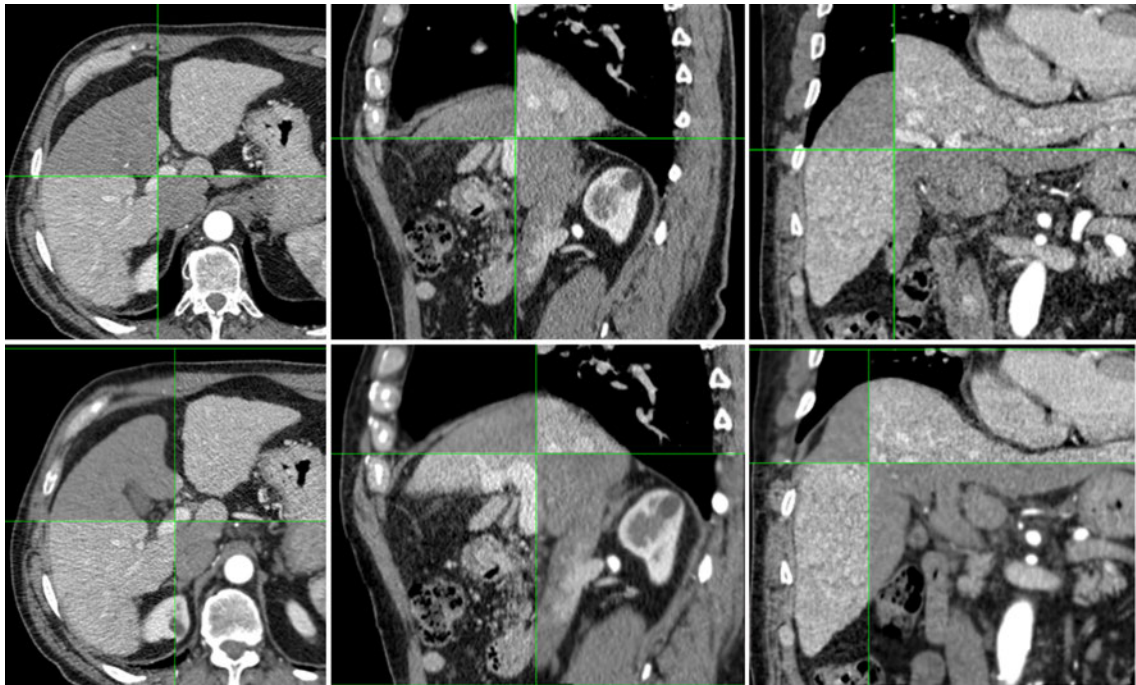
Registration of arterial CT contrast phase with portal venous phase of the liver. The top row shows the alignment before registration and the bottom row shows the alignment after deformable registration. Image taken from [DEOLW12].
